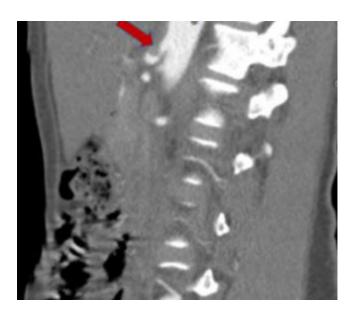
Sagittal image of a CTA of the abdomen demonstrates acute angulation and narrowing of the proximal celiac axis. There is minimal post stenotic dilatation, which overall creates a "hooked" appearance (red arrow) that is characteristic of median arcuate ligament syndrome.
